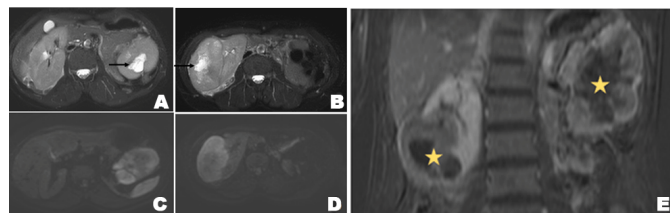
(A–E): Axial T2-weighted image show the two lesions with 2 different signal intensity portions one peripheral solid component and another central necrotic (Black arrow) (A, B). Axial Diffusion-WI Hyperintense components/restricted diffusions are seen in the mass (C, D). Coronal reformatted gadolinium-enhanced 3DFSPGR reveals a heterogeneous enhancement of the tumor (Yellow star) (E).
